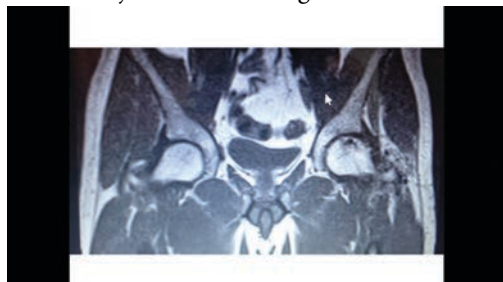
Preinjection MRI Images of the Patient^a
